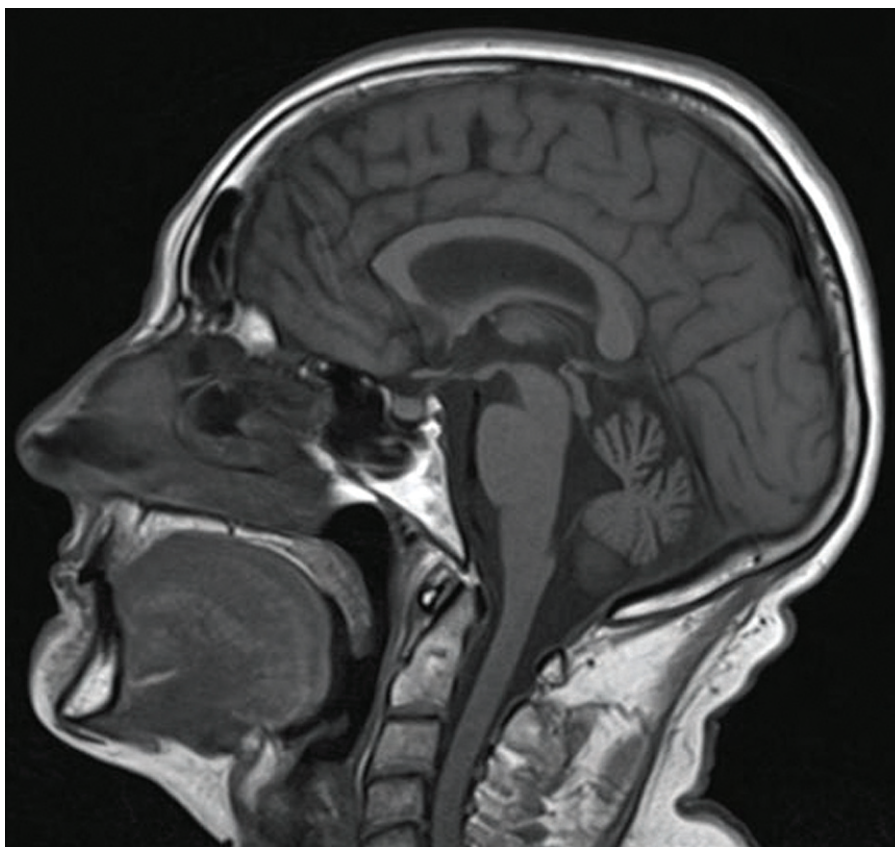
MR imaging demonstrating cerebellar atrophy in a patient with slowly progressive ataxia due to PACA. This patient presented in 1999 at the age of 51. She has the HLA DQ2 and at presentation apart from the ataxia she was positive for thyroid peroxidase antibodies but had normal TSH. She developed hypothyroidism 2 years later. She developed insulin dependent diabetes mellitus 5 years after the onset of the ataxia. Finally she was recently found to have low vitamin B12 with positive parietal antibodies in keeping with pernicious anaemia.
